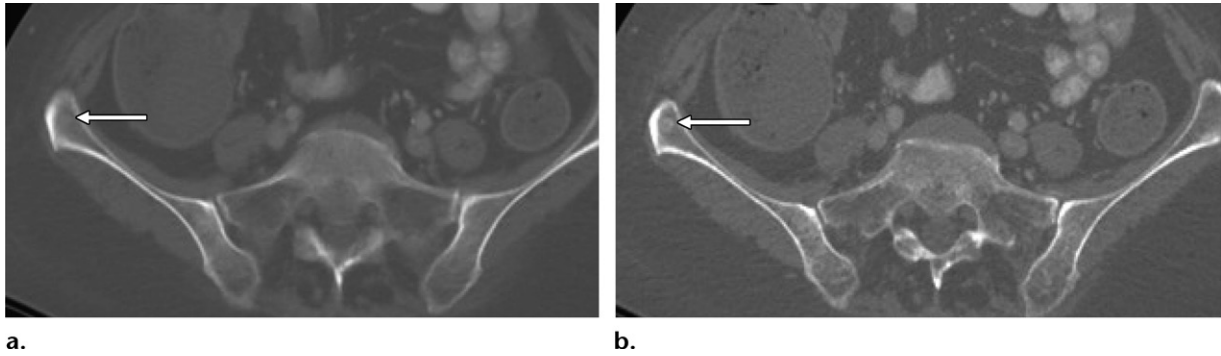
Axial contrast-enhanced abdominopelvic CT images in a patient with lung cancer show that a small osseous metastasis is imperceptible on a 5-mm-thick section (arrow in a) but more conspicuous on a 1.25-mm-thick section (arrow in b).
